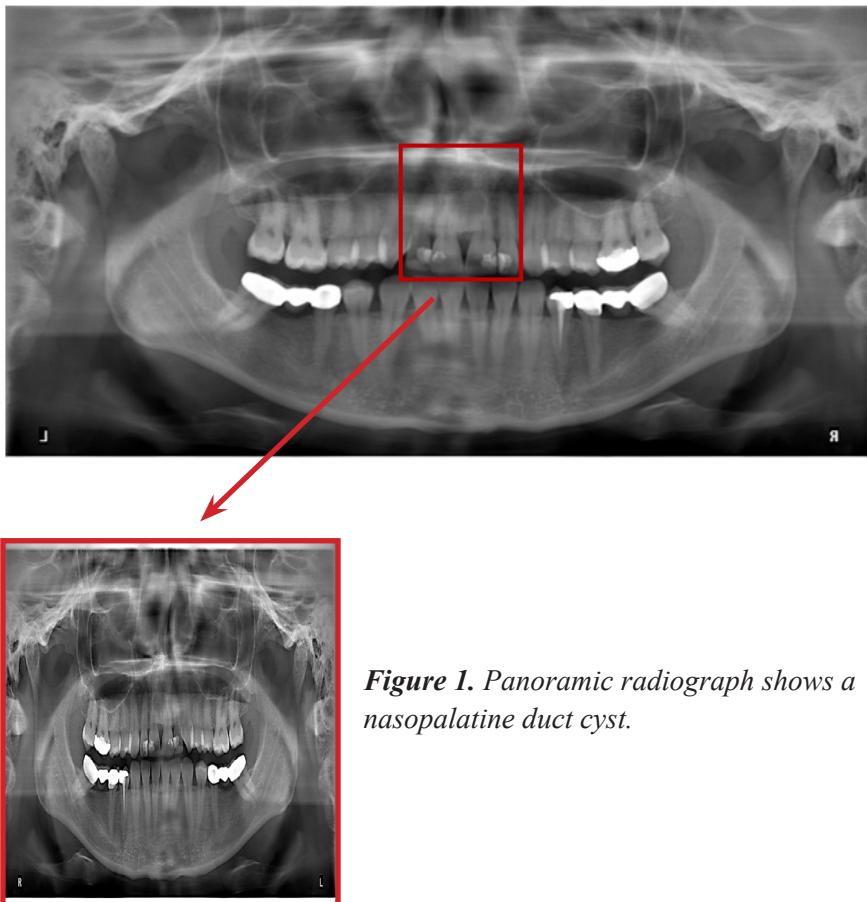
Panoramic radiograph shows a nasopalatine duct cyst.
